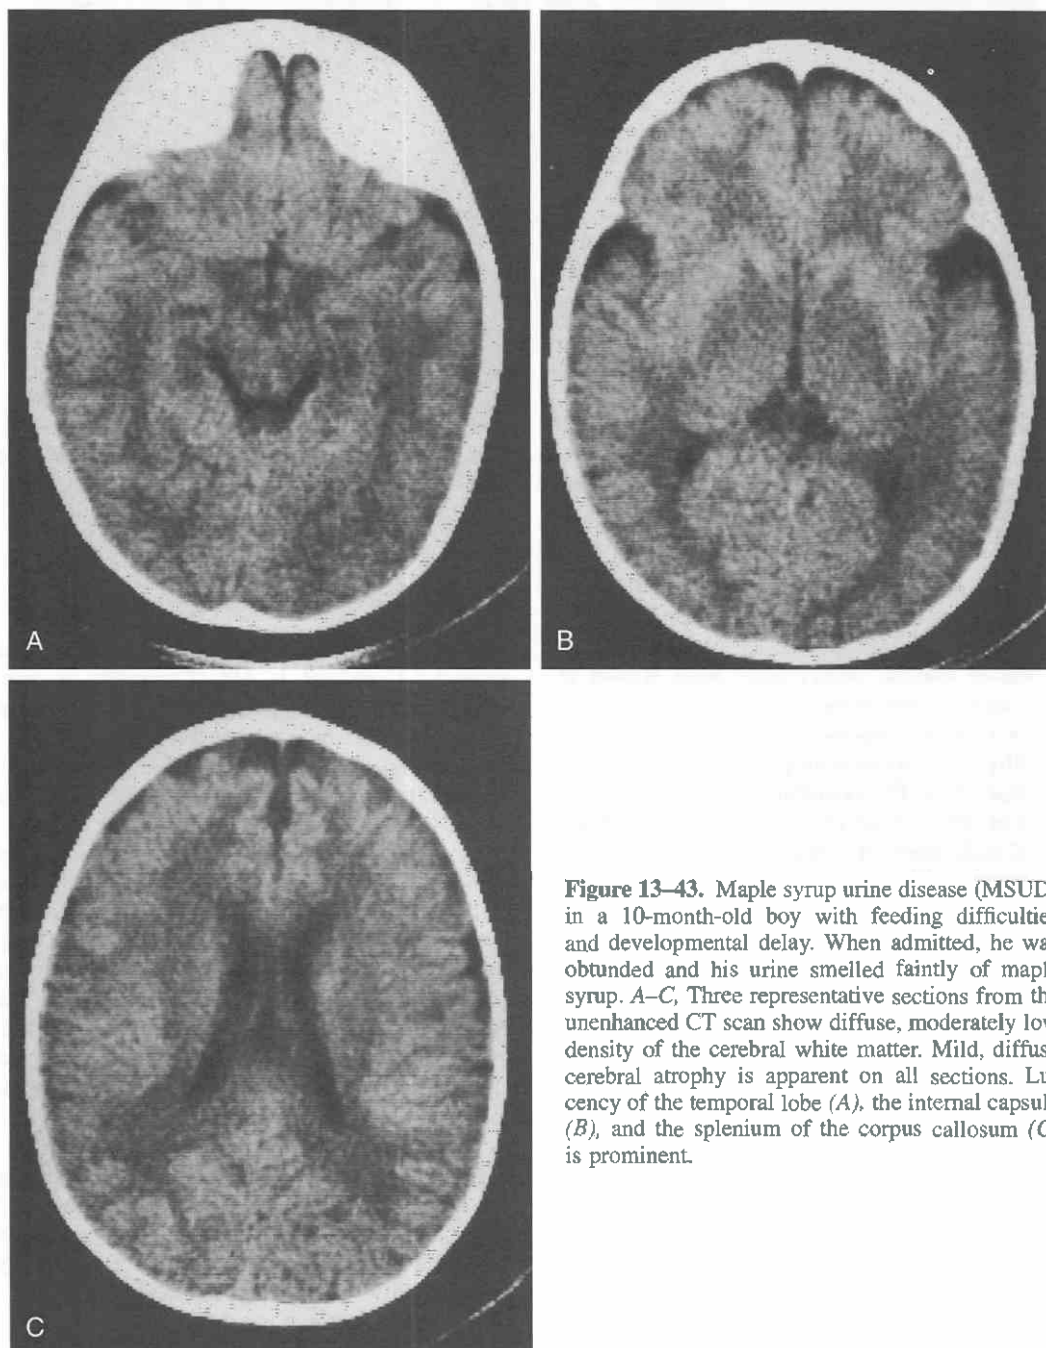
Maple syrup urine disease (MSUD) in a 10-month-old boy with feeding difficulties and developmental delay. When admitted, he was obtunded and his urine smelled faintly of maple syrup. A-C, Three representative sections from the unenhanced CT scan show diffuse, moderately low density of the cerebral white matter. Mild, diffuse cerebral atrophy is apparent on all sections. Lucency of the temporal lobe (A), the internal capsule (B), and the splenium of the corpus callosum (C) is prominent.
